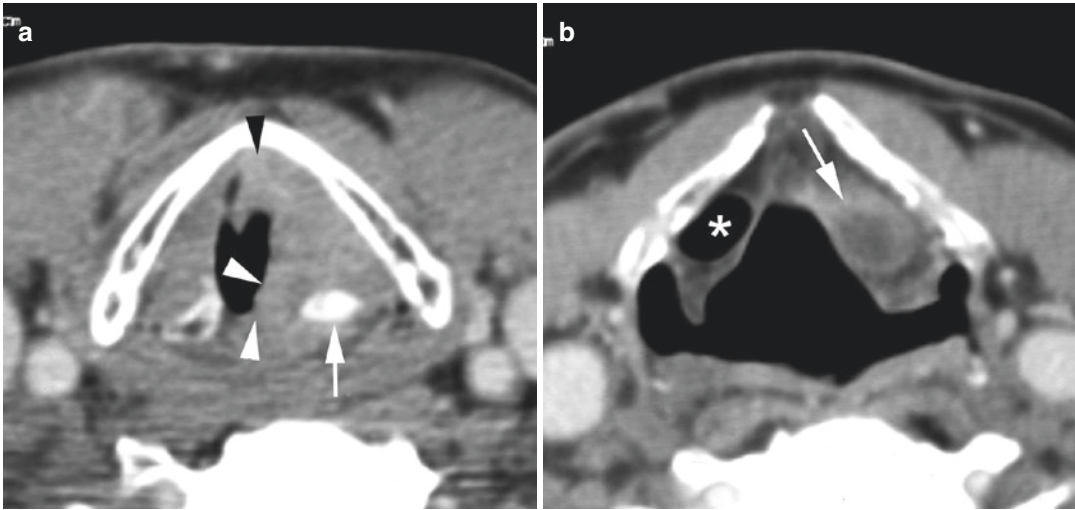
Axial contrast-enhanced CT images in a patient with a clinically T3 glottic cancer on the left side. (a) Level of true vocal cords. The left true vocal cord is markedly thickened. The lesion extends into the anterior commissure (black arrowhead), and grows over the medial facet of the arytenoid into the posterior commissure (white arrowheads). The left paraglottic space is infiltrated. The left arytenoid cartilage
